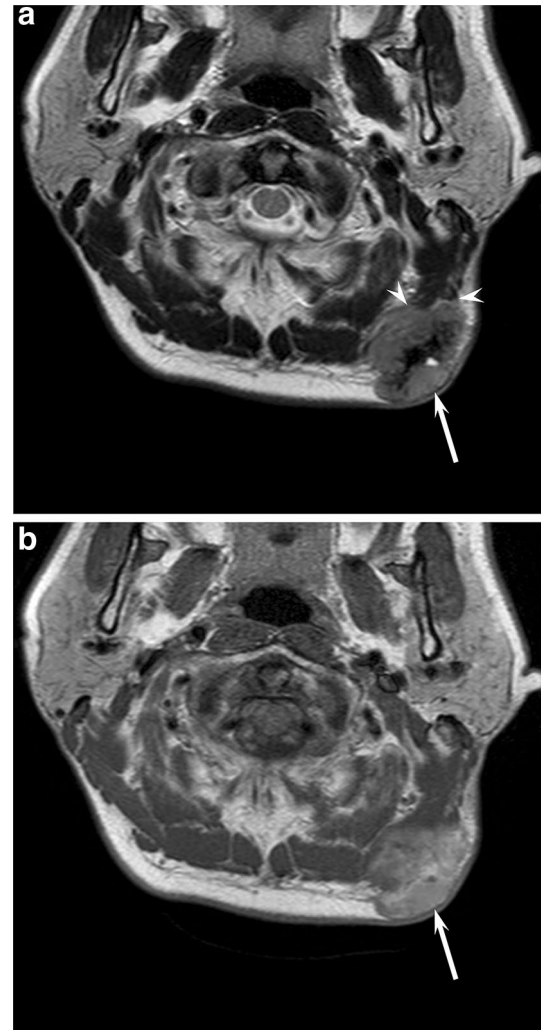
A 52-year-old man with malignant melanoma. a T2-weighted image shows a heterogeneously hypo- to isointense, subcutaneous lesion (arrow) with muscular invasion (arrow heads). b T1-weighted image shows heterogeneous hyperintensity (arrow)
